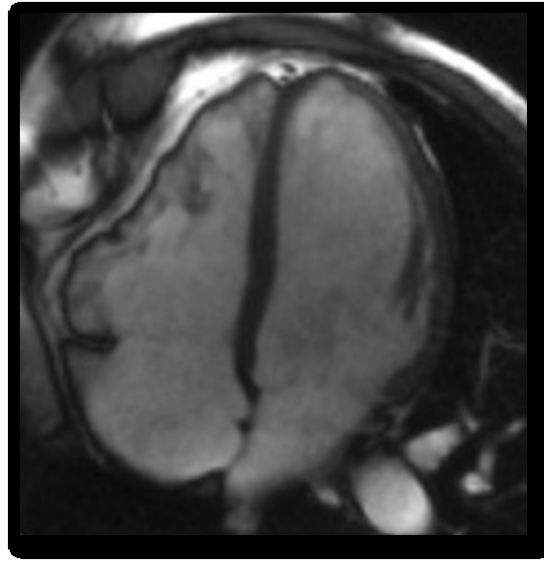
Arrhythmogenic right ventricular cardiomyopathy Long-axis four-chamber steady state free precession cine MRI image demonstrating the characteristic irregular contour of the right ventricular free wall
